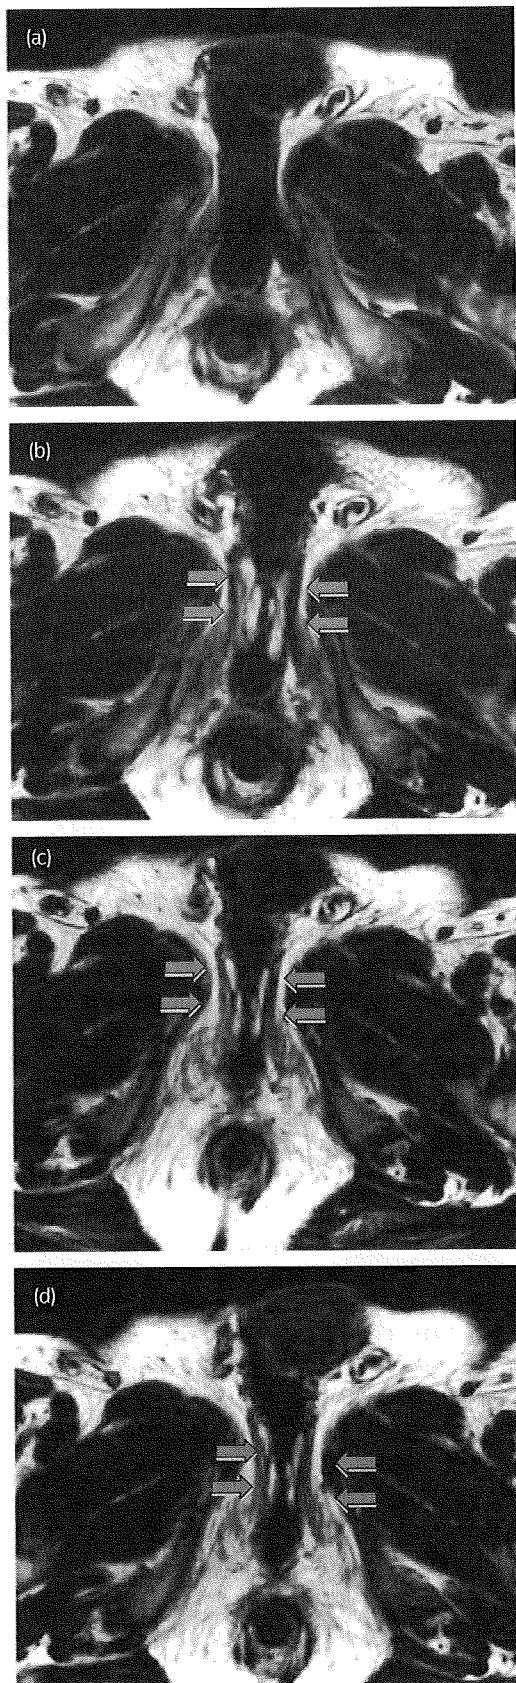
Magnetic resonance imaging around the urethra before and after the adipose-derived stem cells (ADSC) injection. The urethra in Case 1 was visualized as a cross-section on magnetic resonance imaging. (a) Before injection, (b) 4 days after injection, (c) 4 weeks after injection, and (d) 12 weeks after injection. The arrows show the adipose tissue injected with ADSC. At 4 weeks after injection, the volume of injected adipose tissues had decreased compared with that after 4 days after injection. However, the volume did not change thereafter and persisted at 12 weeks after injection.
